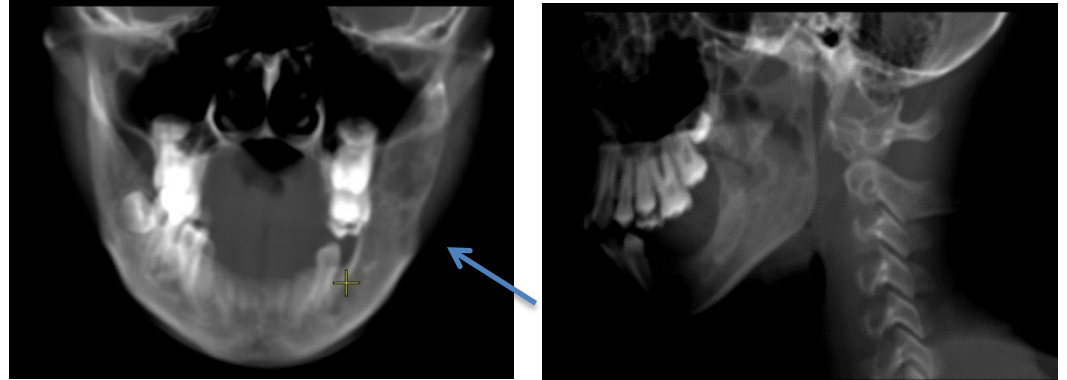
Digital indentation in the area of fibrous dysplasia and upward displacement of the mandibular canal according to teleradiography and computed tomography in boy X.
